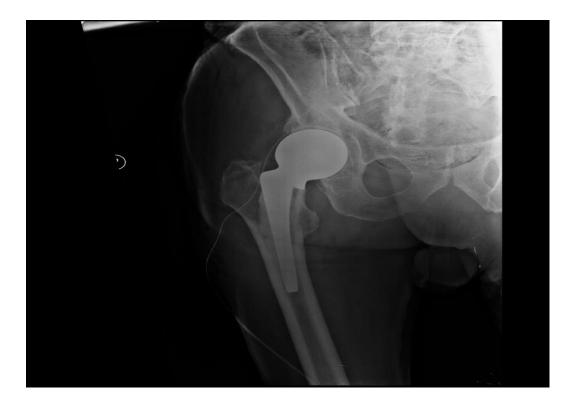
Post operative X-ray interpretation of the right hip Anterior-Posterior. As we described earlier the prosthesis replace the femoral head and it is composed of a metal stem which fits into the marrow cavity of femur and a metal ball that fits into the acetabulum. (From patient's documentation)
